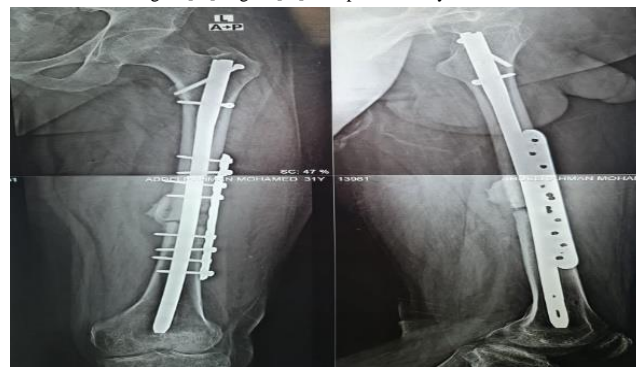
Postoperative follow up X-ray of case 1 after 1 month.
